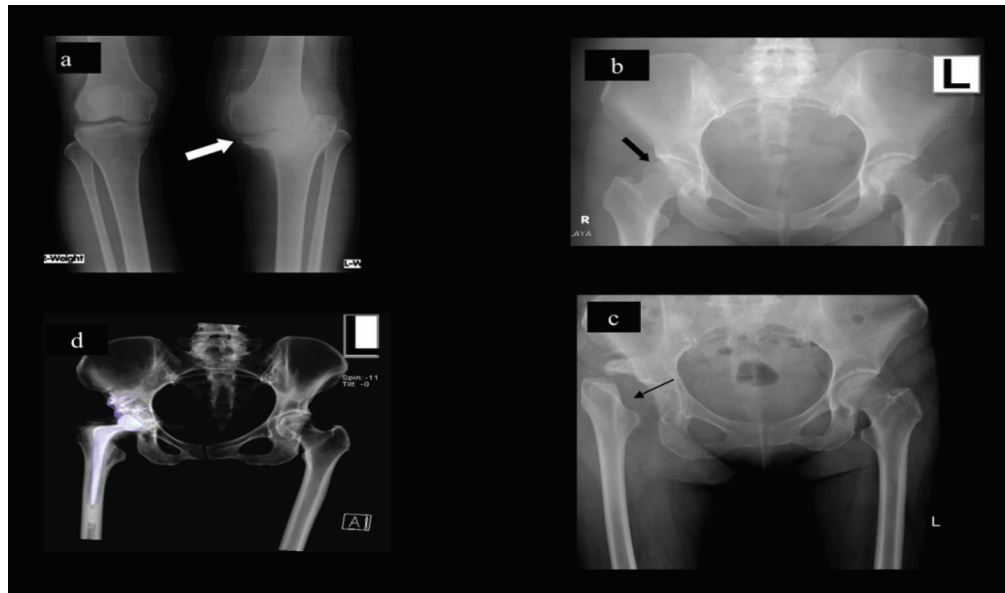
(a) Marked bony destruction of the left proximal tibia noted (white arrow). (b) Pelvic radiograph showing a normal head of right femur (black thick arrow). (c) The head of right femur is completely destroyed (black thin arrow) within one year of patient presenting with right hip pain. (d) Coronal MPR CT scan showing right THR metal prosthesis that had been inserted for the patient to replace the destroyed head of right femur.
